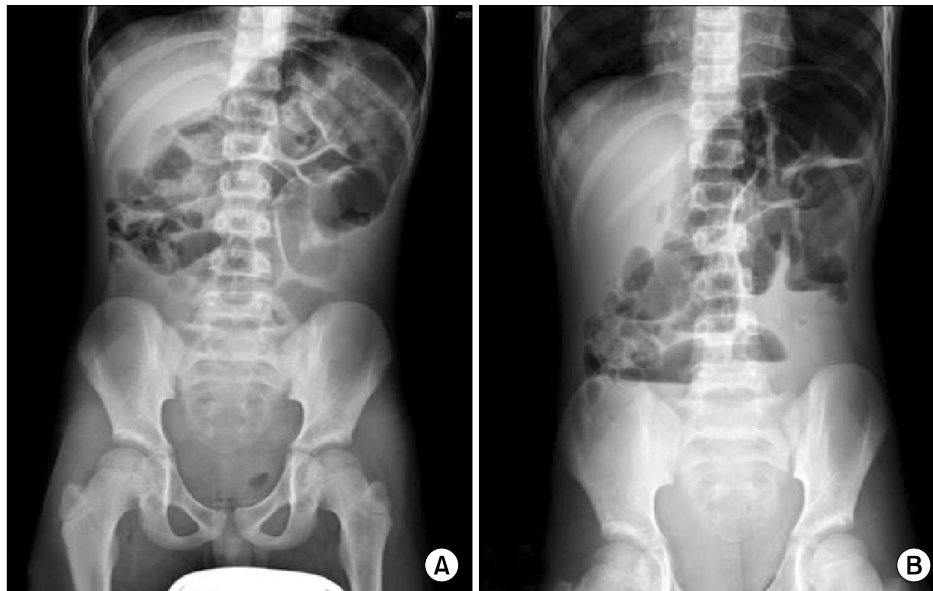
A plain x-ray of the abdomen (A: supine view, B: erect view) showing a mechanical small bowel obstruction with 'step-ladder' air-fluid pattern in the erect film.
